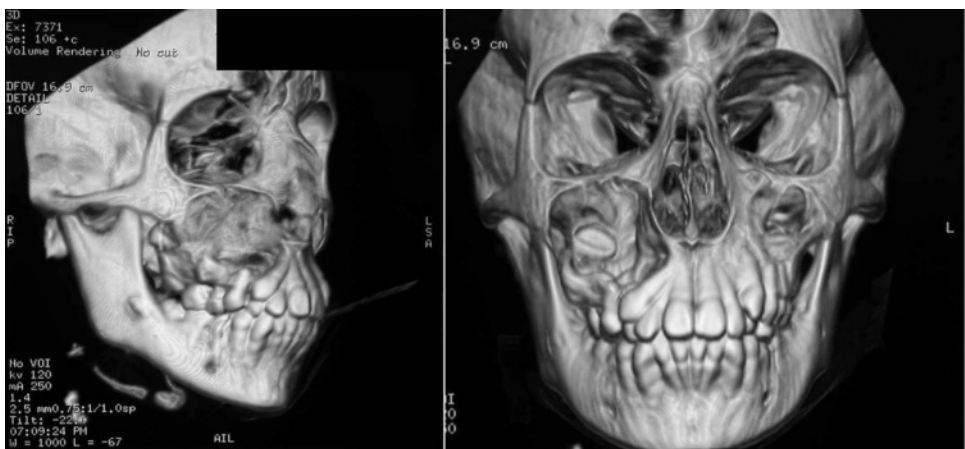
Three-dimensional rendering of cone beam computed tomography imaging data for a dentigerous cyst of the right posterior maxilla. Notice the tooth crown protruding into the cyst lumen.
